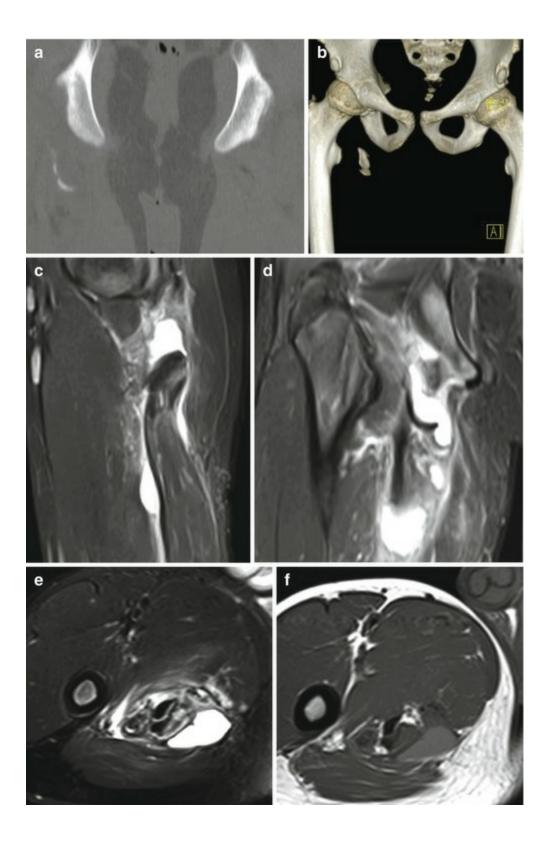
A 13-year-old boy with apophyseal avulsion fracture of the ischial tuberosity. Coronal MRI (a) and 3D reformatted CT image (b) demonstrate the presence of a displaced fragment of the inferolateral portion of the right ischial tuberosity. Sagittal (c) and coronal (d) fat-suppressed proton density-weighted MRI show the retracted and torn hamstring tendons. Note also the associated hematoma on axial fat-suppressed proton density (e) and T1-weighted (f) MRI. (g) Anteroposterior radiograph of the right hip taken after surgical treatment reveals internal fixation of the ischial apophysis
